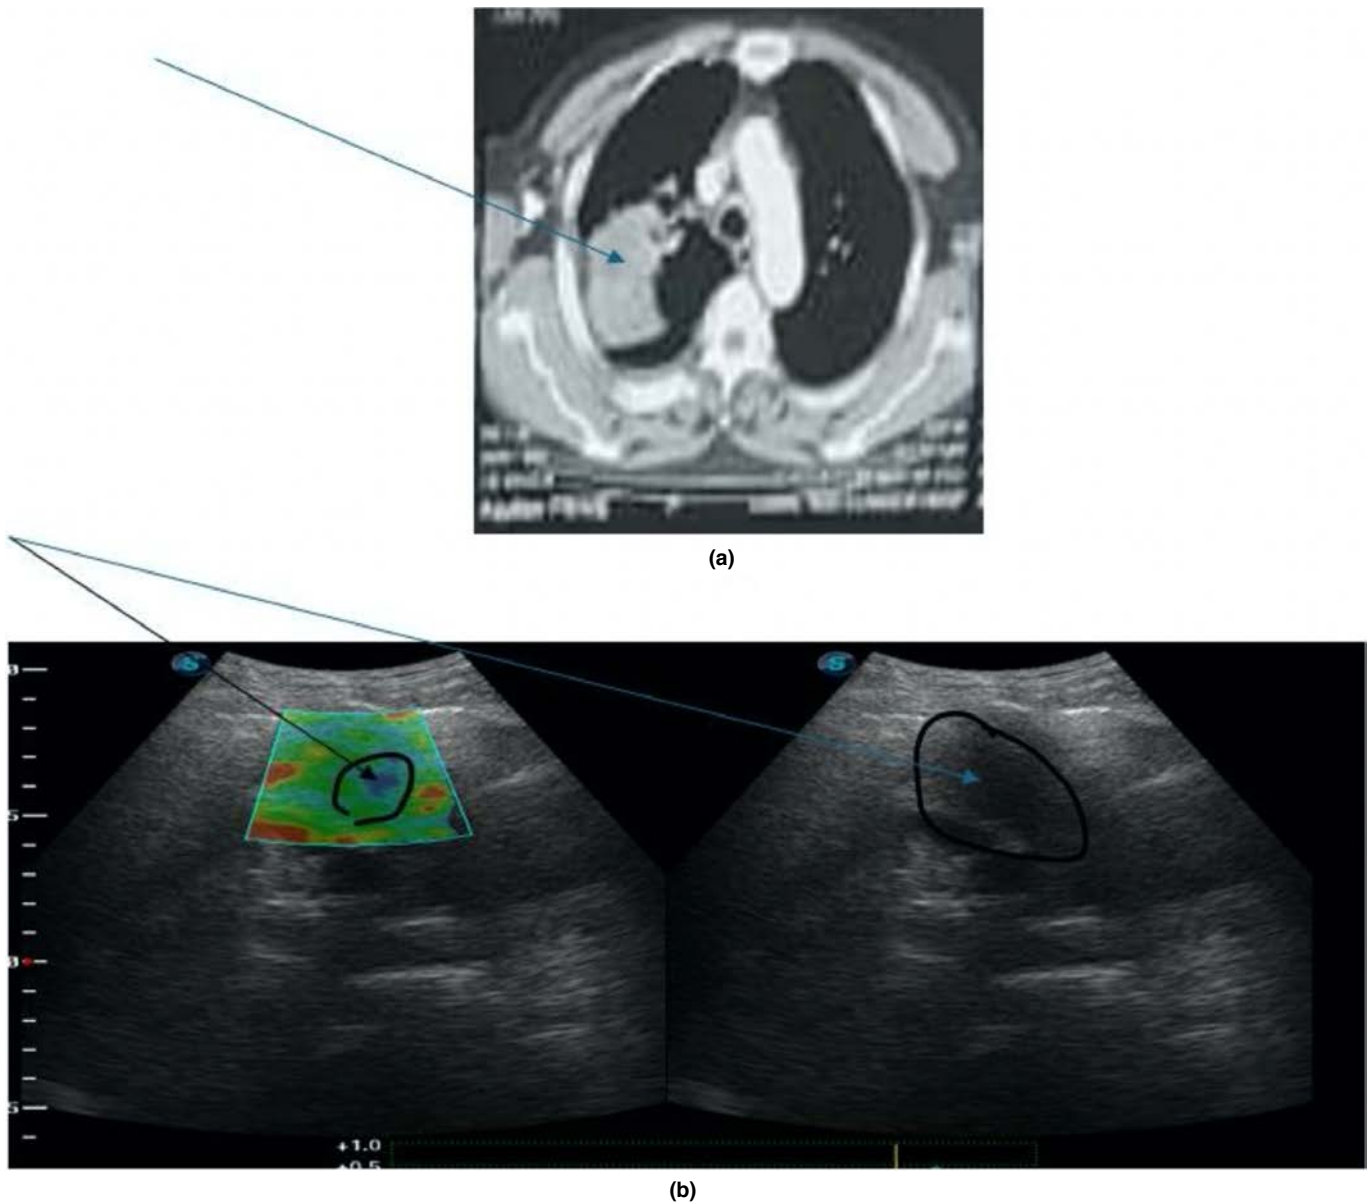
Computed tomography (CT) chest of a left soft tissue lesion with corresponding ultrasound elastography examination. Figure 6 describes a patient presenting with significant weight loss over two months and progressively worsening dyspnea. Transthoracic ultrasound-guided biopsy confirmed small cell lung carcinoma with a strain ratio (SR) of 2.34. (a) CT chest (mediastinal window) reveals a right peripheral soft tissue lesion. (b) B-mode ultrasound depicts an irregular, ill-defined hypoechoic lesion, while elastography highlights a hard lesion with a blue component
